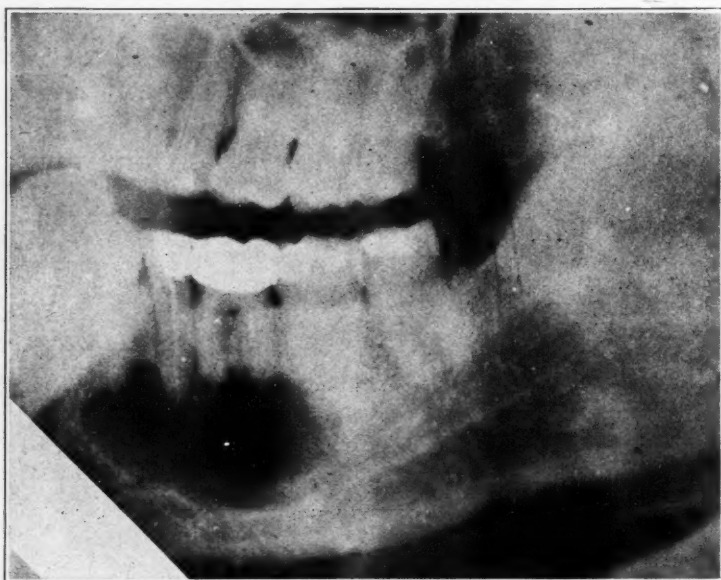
Large area of bone destruction on right side of mandible due to cyst formation probably arising in connection with irritation following periapical infection about the second premolar and first molar. Observe sharp outline of cavity.
